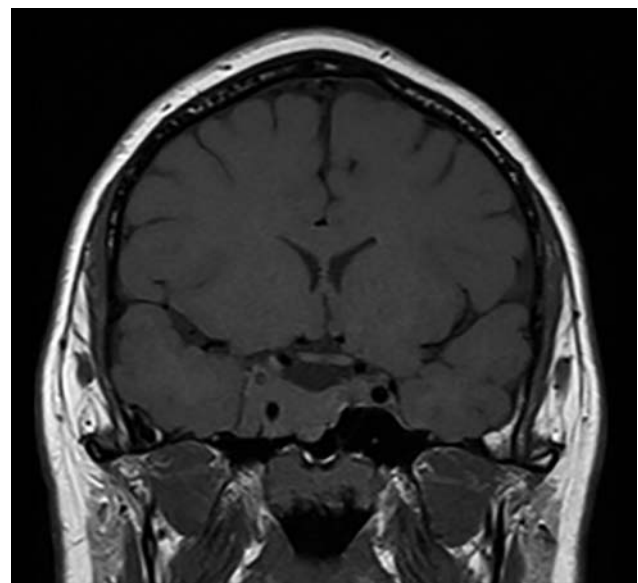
T1-weighted coronal MRI pituitary – view following 6 months of cabergoline treatment showing significant tumour shrinkage.
